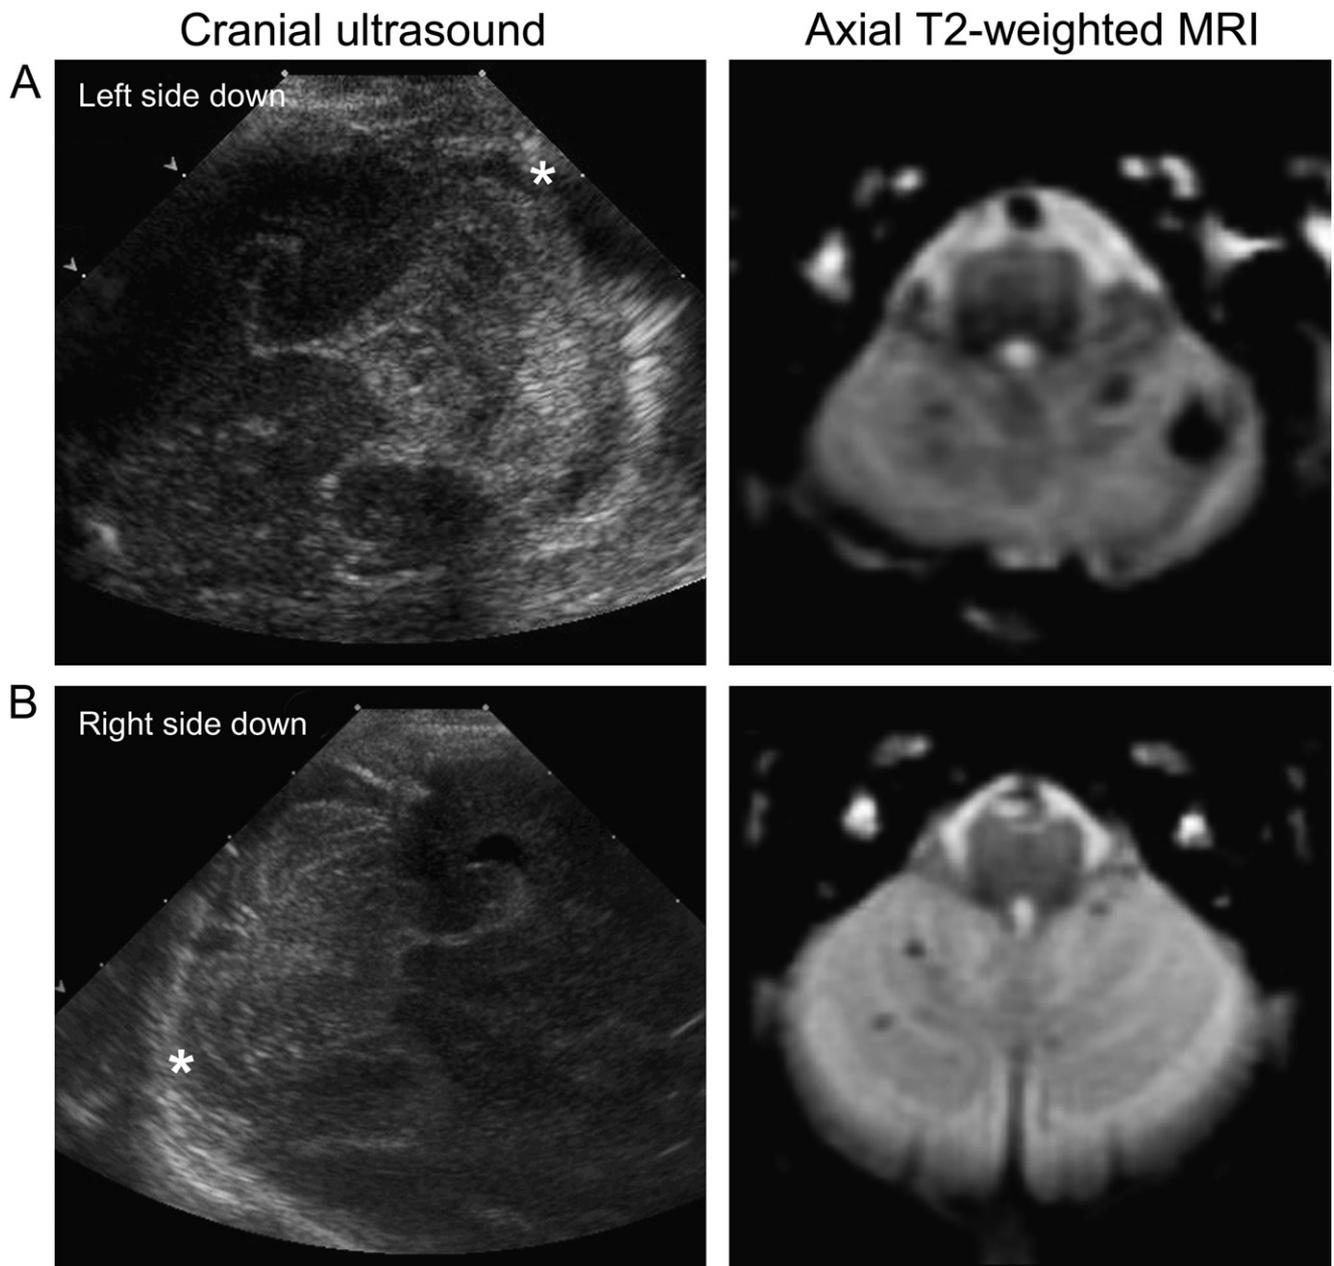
Appearance of cerebellar hemorrhage on MRI and cranial ultrasound in a newborn with A, ultrasound-visible cerebellar hemorrhage and B, a newborn with cerebellar hemorrhage detected only by MRI. A, The patient in died during the perinatal period, whereas B, the patient in had normal neurodevelopmental outcomes at 4.5 years. The right cerebellar hemisphere is indicated by an asterisk.
